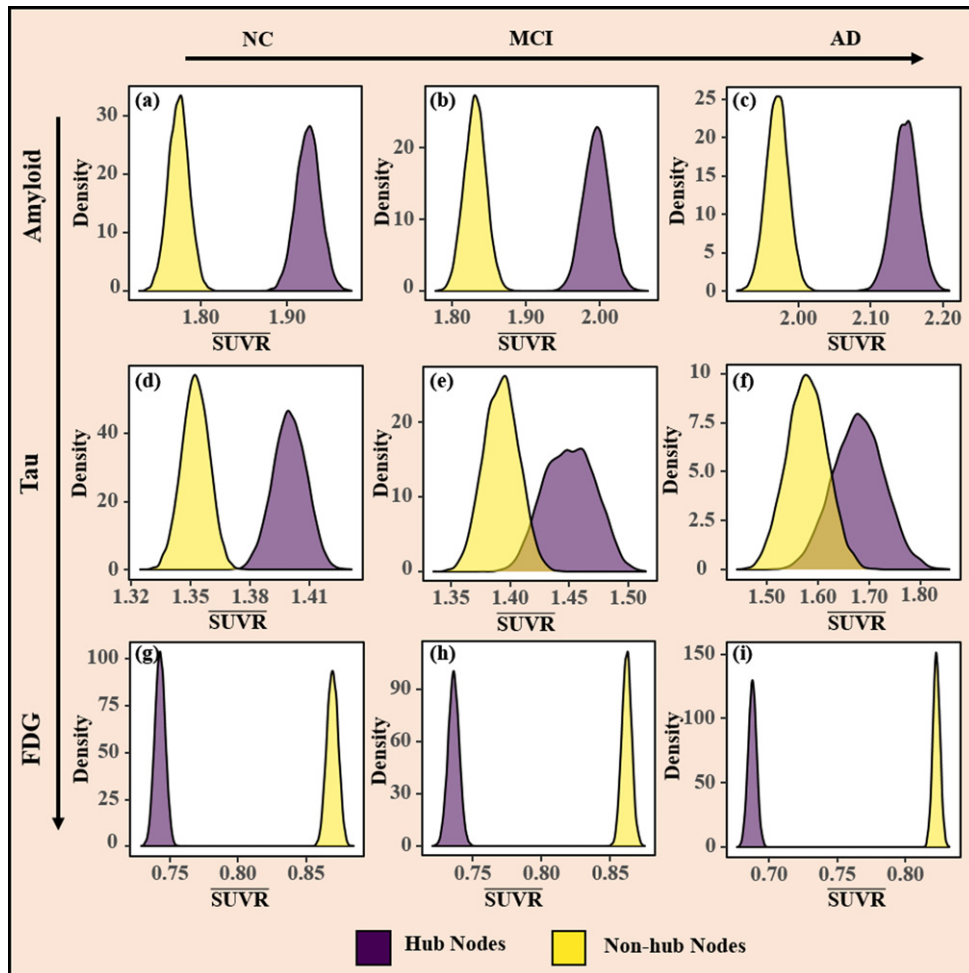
Density plots of pathological damage levels using bootstrap samples taken from NC, MCI, and AD cohorts. Based on bootstrap samples, subfigures show posterior densities of mean amyloid- β SUVR levels (a,b,c), tau (d,e,f), and FDG (g,h,i). Purple and yellow colors are used to describe the results of the hub and non-hub nodes, respectively.
